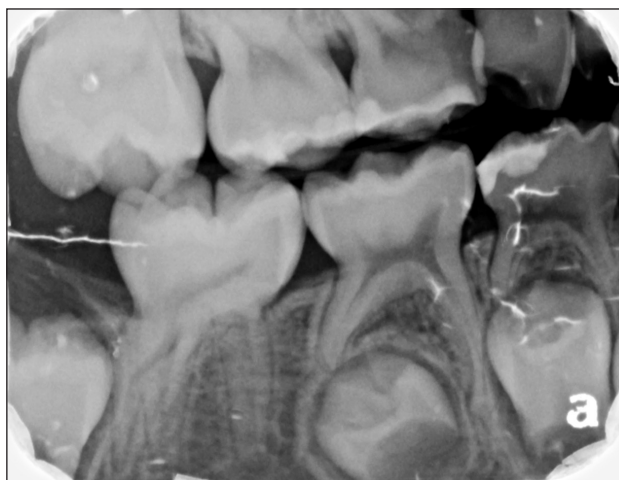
Case one right bitewing radiograph. Note the cervical constriction and abnormal root morphology of the permanent mandibular first molar and incipient carious lesion on its mesial surface.
